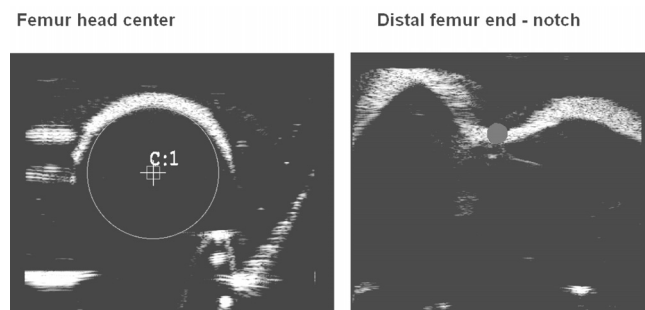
Definition of femur length on ultrasound scans
